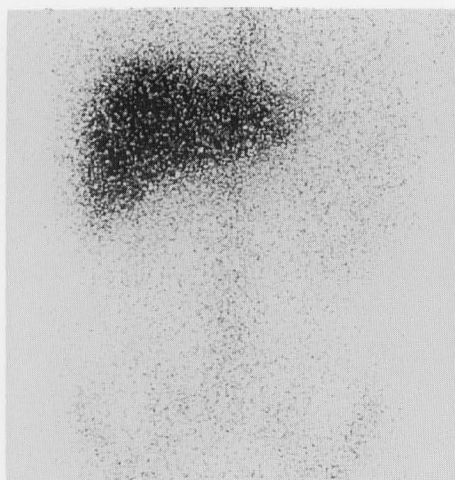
On Ga-67 scintigraphy performed 2 weeks after injection of streptomycin, accumulation of radioactivity in the upper abdomen disappeared.
